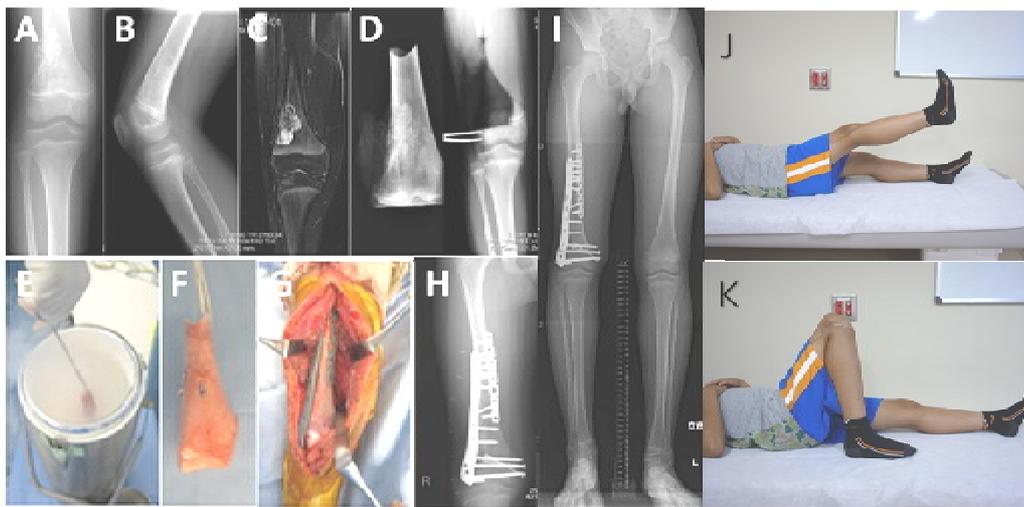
Case presentation representing a ten years old boy at time of surgery with osteosarcoma distal right femur. A,B: Anteroposterior and lateral view of distal femur XP showing the tumor mass. C: T2 weighed MRI image of the distal femur showing the tumor mass with high signal intensity. D: Intraoperative XP showing the freely resected segment to be frozen, and the host bone. E: Intraoperative photo of free freezing. F: The tumor bearing bone after freezing. G: The frozen segment after repositioning and fixation. H: Post-operative XP of the distal femur after freezing and fixation. I: Long leg film showing the LLD of 3 cm. J,K: Clinical photo of the knee in full flexion and full extension.
